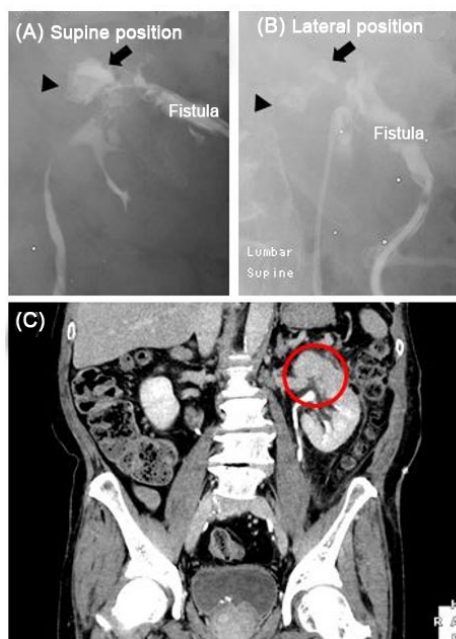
(A, B) Fistulography revealed a slightly dilated upper calix (arrow) ventral to the renal stones (arrow head). (C) Enhanced computed tomography in excretory phase could not demonstrate the upper calix or its communication with the renal pelvis (circled area).
